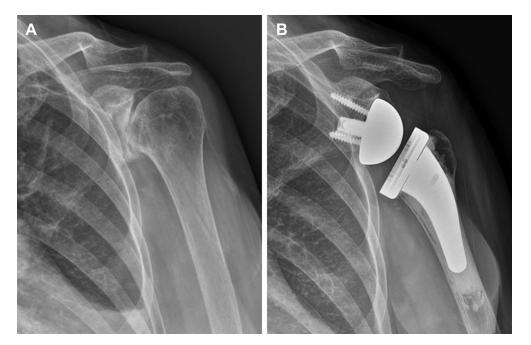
(A) Preoperative radiograph of a 63-year-old patient with rheumatoid arthritis showing the Favard type E1 glenoid. (B) Postoperative radiograph taken 26 months after reverse shoulder arthroplasty.
